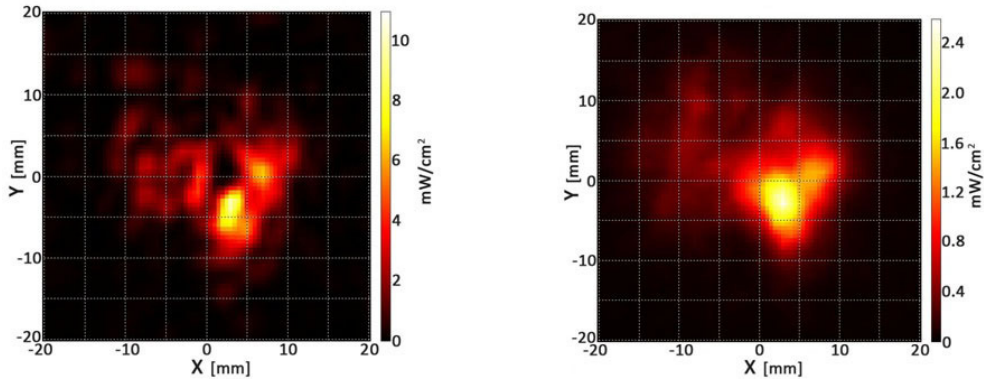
Two-dimensional distribution of ultrasound intensity with bone for sinusoidal signal (left) and RSBIC signal (right). The UI_{2D} is 566 for sinusoidal case and 266 for sinusoidal case. The carrier frequency was 500k Hz and the activating voltage was 13.3 Vpp. The band of the noise which was used for RSBIC signal was from 50 kHz to 200 kHz. The diameter of the transducer was 24mm. The distance from the surface of the transducer was 15mm
